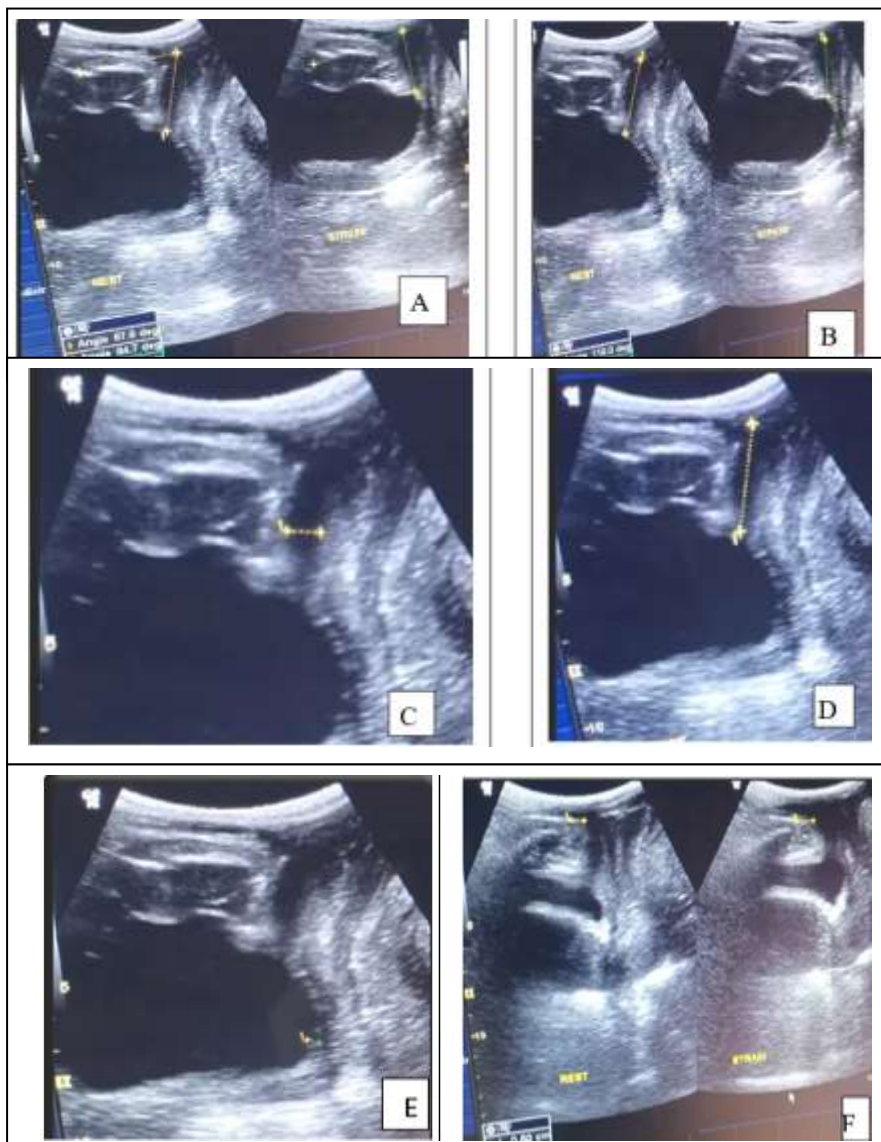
Female patient, 30 year old, complaining of SUI, Transperineal ultrasound showed; Alpha angle at rest was 67.6 degrees while at stress was 84.7 degrees with difference between them 17.1 degrees (A). Beta angle at rest was 119 degrees while at stress was 154.3 degrees with difference 35.3 degrees (B). Urethra was 3.4 cm length and 7 mm width (C,D). Bladder wall thickness was 3 mm (E). The pubo-urethral distance at rest was 5 mm while at stress was 8 mm (F).
